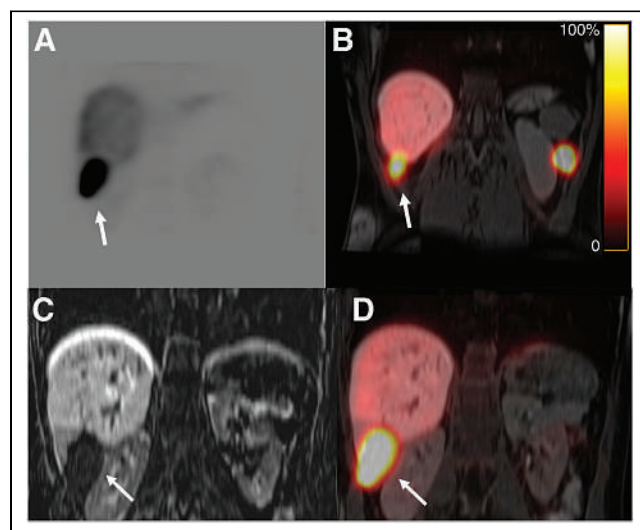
(A and B) $^{99\text{m}}\text{Tc}$ -labeled heat-damaged red blood cell SPECT/CT images show increased uptake in hepatic (A) and left flank (B) splenule. (C and D) Coronal T1-weighted MR (C) and SPECT/MR (D) images show intrahepatic splenosis in unusual location (arrows).
